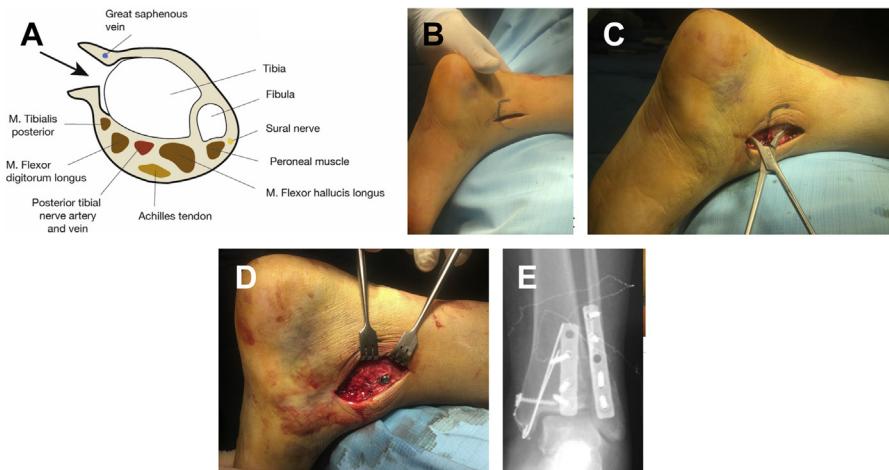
Medial approach. Anatomic considerations. (A) A 5-cm skin incision (prone position) is made. (B) Reduction of the medial malleolus with a clamp. (C) Tension band for medial malleolus fracture. (D) Postoperative radiographs after open reduction and internal fixation of the posterior and lateral malleolus (E).
